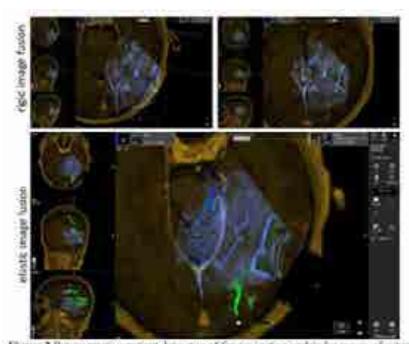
Representative patient dataset used for navigation update by means of submattic rigid (top row) and clastic (bottoo) row) MR-US larger flaston. Initial rigid allgement of MRI and iUS data acquired after resection is cognized to suspert elastic image flaston resulting in a 3D deformation vector field (visualized by arrows showing greatest magnitudes in visuals beneath the resection (arrows).
